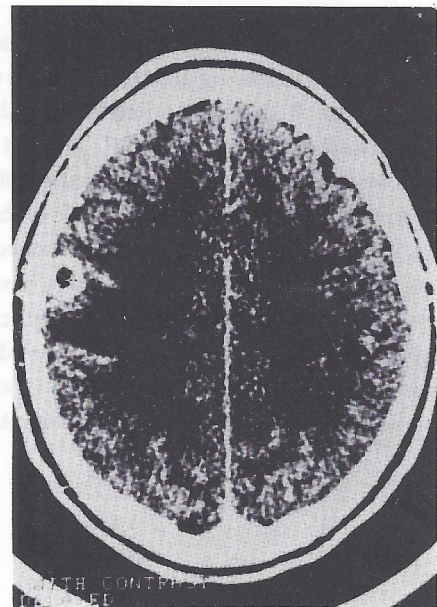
Contrast enhanced CT scan showing a ring enhancing low attenuation lesion with surrounding oedema.
